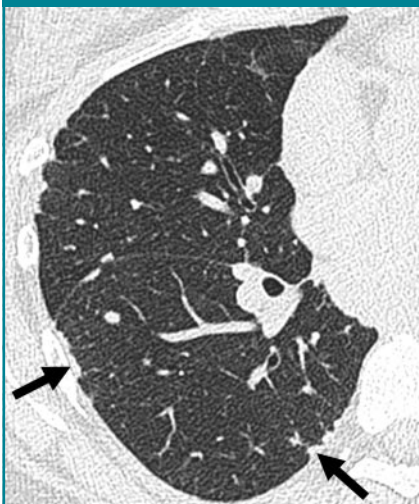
Transverse CT scan shows pseudoplaques (arrows) in a patient with sarcoidosis.
